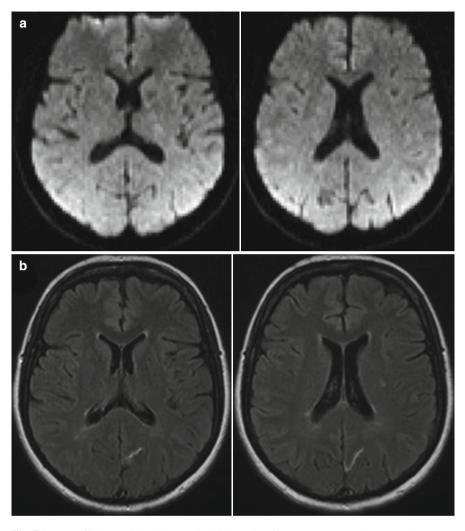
(a) Diffusion-weighted image (DWI) 3 weeks after symptom onset does not show acute signs of ischemia anymore, (b) small laminar necrosis in the occipital cortex suggests migrainous infarction in fluid-attenuated inversion recovery (FLAIR) sequence
